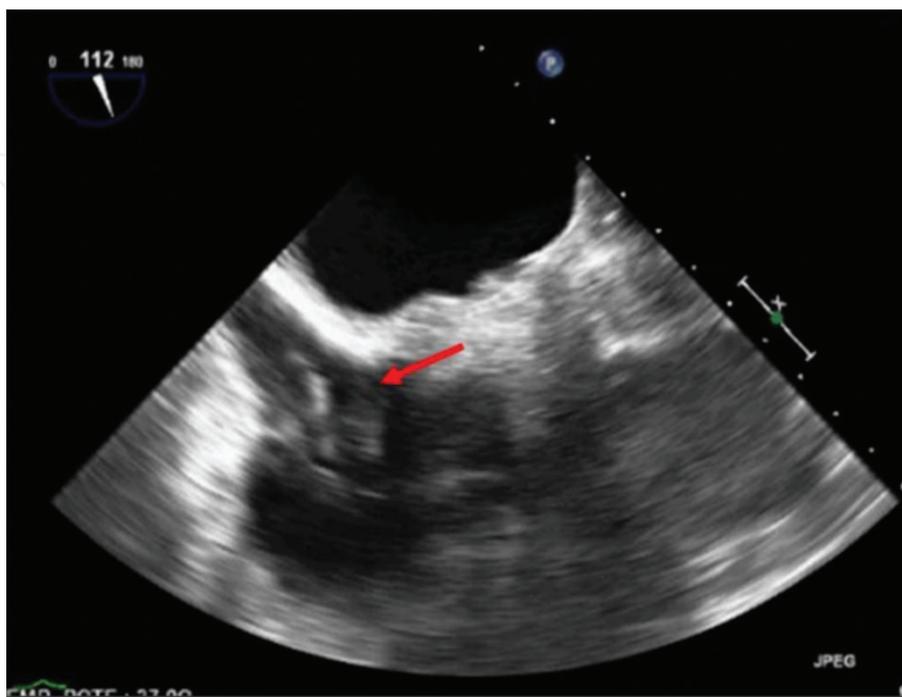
Transesophageal echocardiogram: a hyperechoic lesion (red arrow) is seen at level of pulmonary valve, prolapsing to right ventricle outflow tract.
